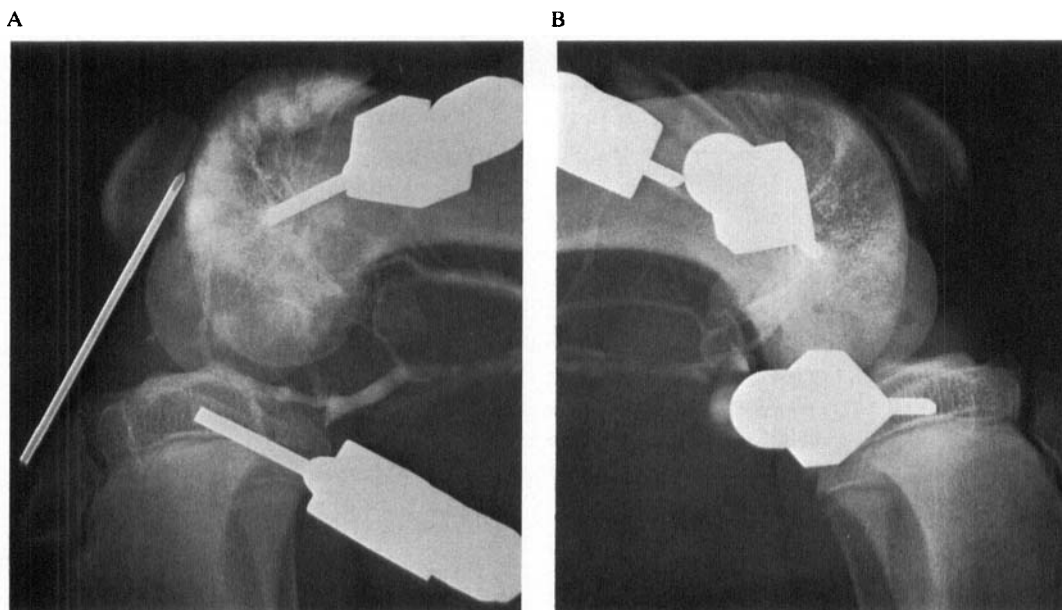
A + B, Intraosseous phlebography during injection of X-ray contrast (30 s) demonstrate accumulation of contrast in the arthritic epiphysis (A) particularly in the trochlea. The epiphyseal draining veins are dilated compared to the control epiphysis (B), where no accumulation of contrast was observed.
